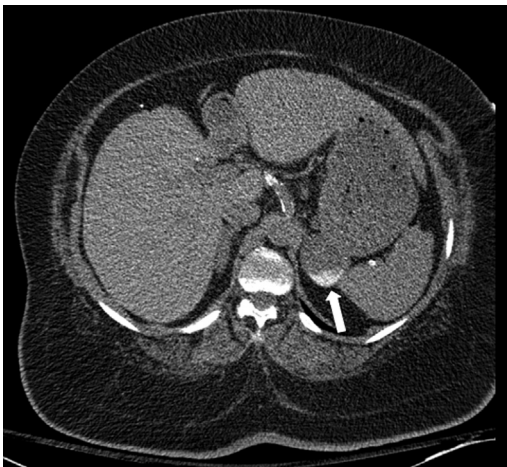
Gastric diverticulum. A 49-year-old man with shortness of breath. Axial image from chest CT performed without intravenous contrast reveals a gastric diverticulum (arrow) emanating from the posterior gastric fundus, a typical location for a gastric diverticulum. Layering hyperdense debris helps to distinguish the finding from other entities, such as an exophytic gastric mass.
